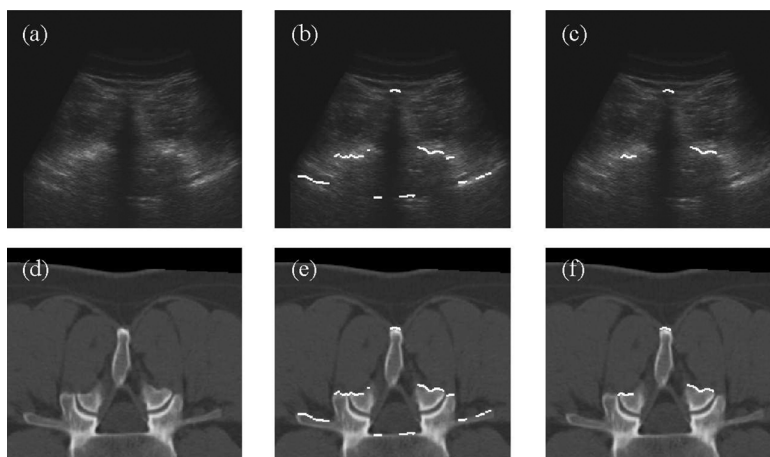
(a) Preoperative axial ultrasound image. (b) Complete bone surface at the registered position of one vertebra. (c) Bone surface of one vertebra at the registered position. (d)–(f) Corresponding registered CT slices.
